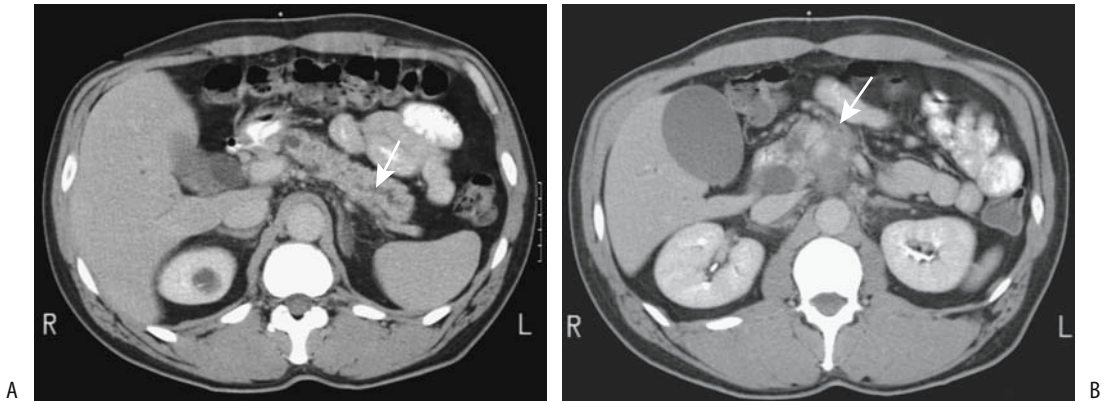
Pancreatic head carcinoma. A: Contrast-enhanced CT reveals a dilated pancreatic duct (arrow). B: An image slightly inferior also identifies a poorly enhancing tumor in the pancreatic head (arrow). (Courtesy of Patrick Fultz, M.D., University of Rochester.)
